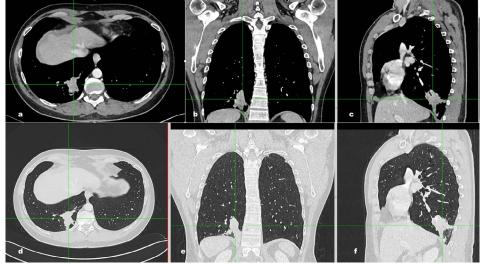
(3a-f) Axial (3a,3d), coronal (3b,3e) and sagittal (3c,3f) thin-section contrast-enhanced CT scan in portal venous phase (3a-c: mediastinal windowing; 3d-f: lung windowing) show a parenchymal consolidation measuring approximately 60x40x40 mm in the posterior segment of the right lower lobe. This lesion is characterized by irregular margins with strands extending to the hilar region and adjacent pleural plane.
